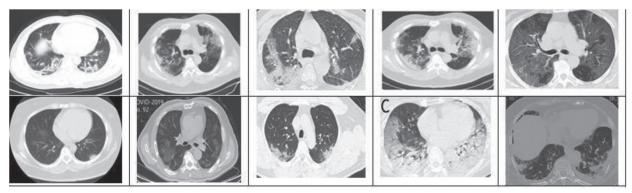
COVID affected images from CT scan Dataset
